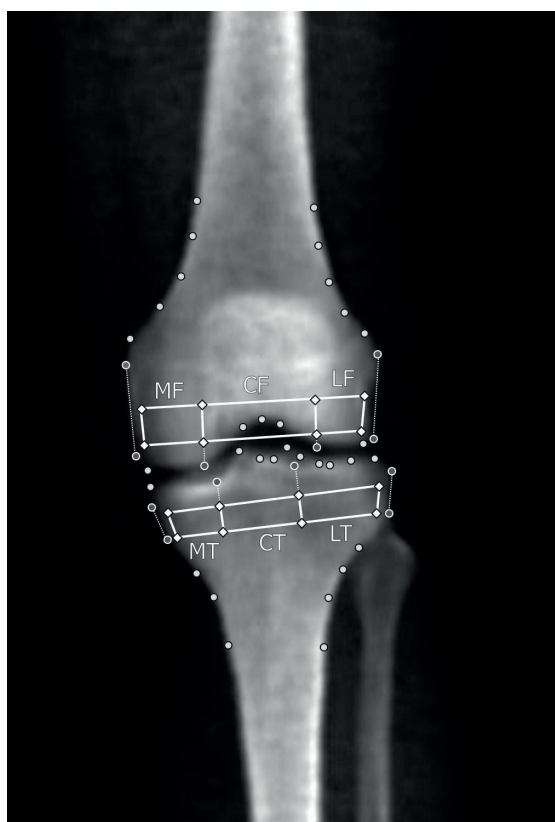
Determination of six regions of interest (ROIs) by using landmark points. 1: medial tibia (MT), 2: central tibia (CT), 3: lateral tibia (LT), 4: medial femur (MF), 5: central femur (CF), 6: lateral femur (LF). (Published with permission of B.L. van Meer)
